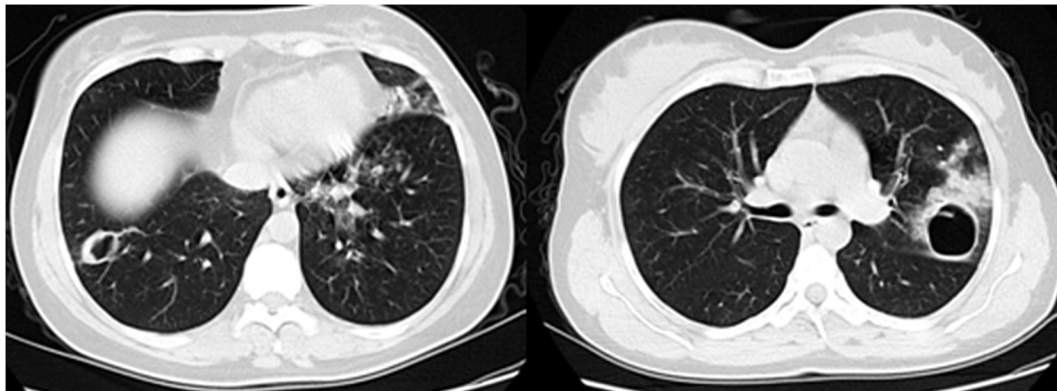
Non-contrast thorax CT axial images shows perforated cystic areas in the left upper lobe posterior segment and right lower lobe superior segment of lungs.
